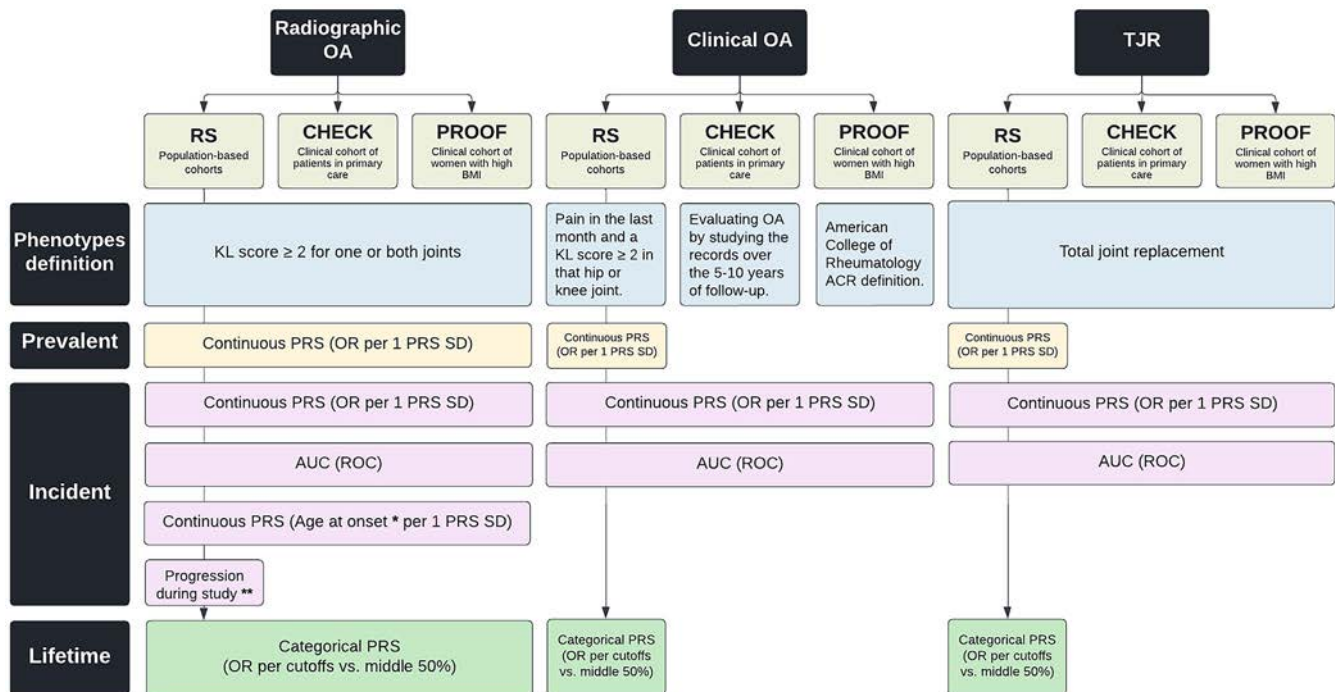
Overview of data availability and performed analysis. * = Age at onset was determined for incident radiographic osteoarthritis (OA) and was calculated as the age at first diagnosis of radiographic OA.  = Radiographic OA progression was defined as any progression in the Rotterdam Study (RS) with a ≥ 1 -degree increment in Kellgren/Lawrence (K/L) score (excluding progression from K/L 0 to K/L 1 or having a total joint replacement [TJR] of one or both joints during the follow-up period). CHECK = Cohort Hip and Cohort Knee; PROOF = Prevention of Knee Osteoarthritis in Overweight Females; BMI = body mass index; PRS = polygenic risk score; ROC = receiving operating characteristic curve; AUC = area under the ROC; OR = odds ratio. Color figure can be viewed in the online issue, which is available at <http://onlinelibrary.wiley.com/doi/10.1002/art.42246/abstract>.
